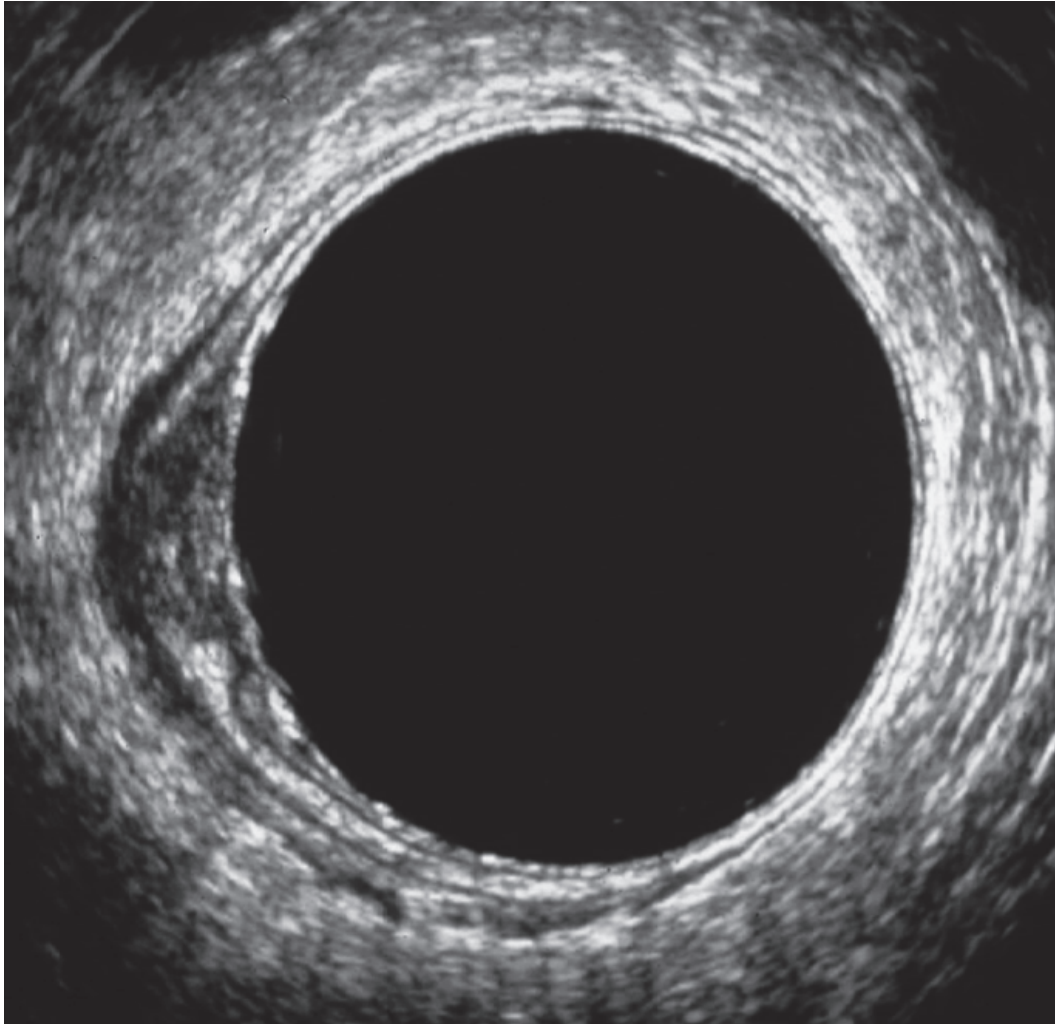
Sonographic diagnosis of tumor invasion of the muscularis propria (uT2) is based on thickening of this layer
